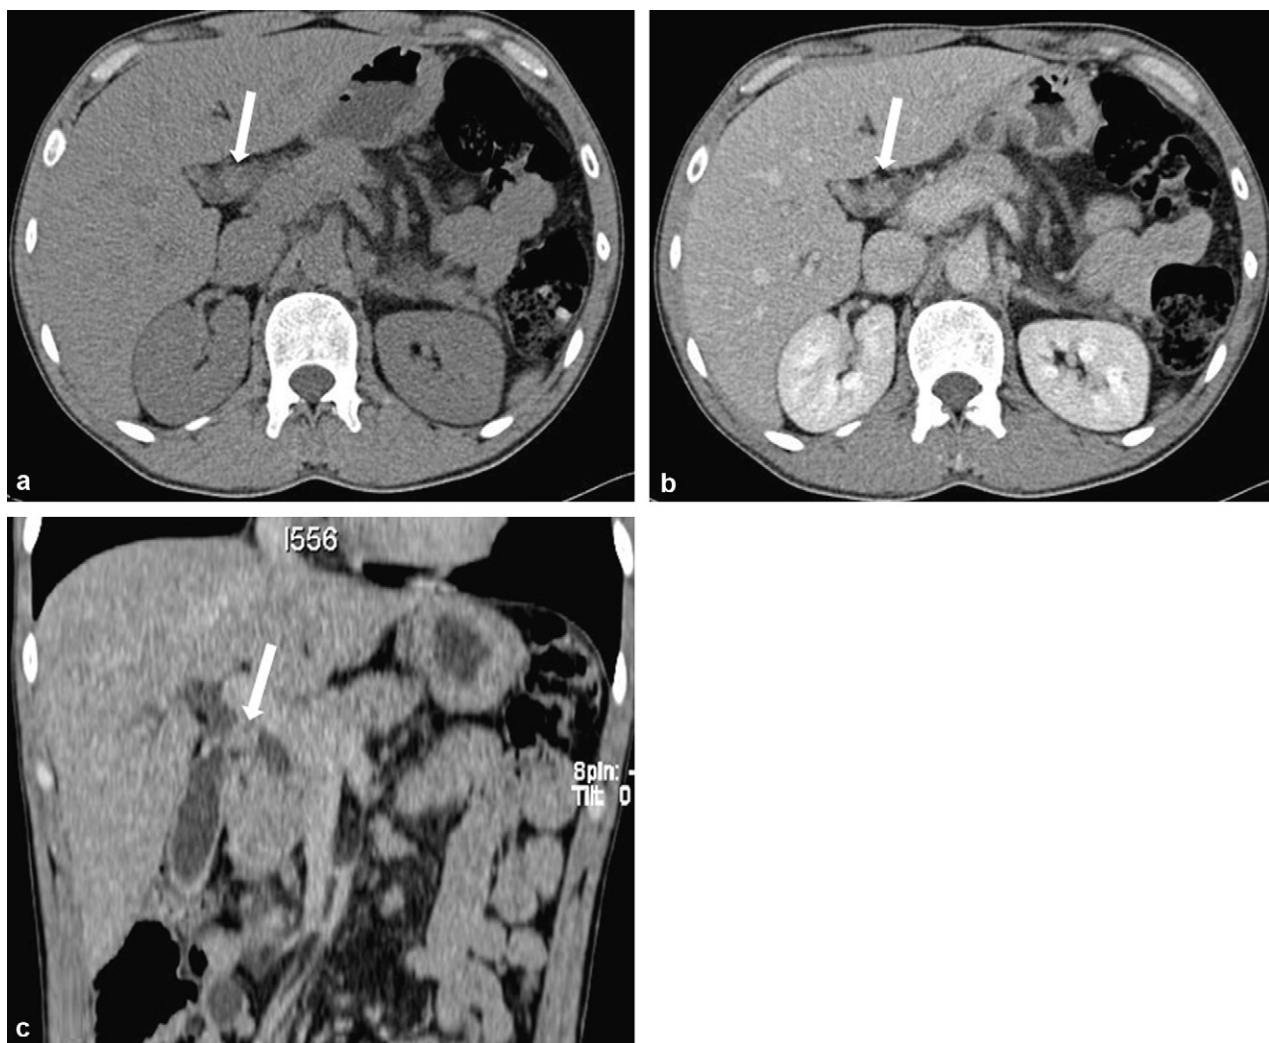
Abdominal axial CT before (a) then after injection of a contrast agent (b) and frontal reconstruction (c). Proximal common bile duct tissue mass measuring 15 mm, occupying the lumen of the duct with a preceding dilatation.
